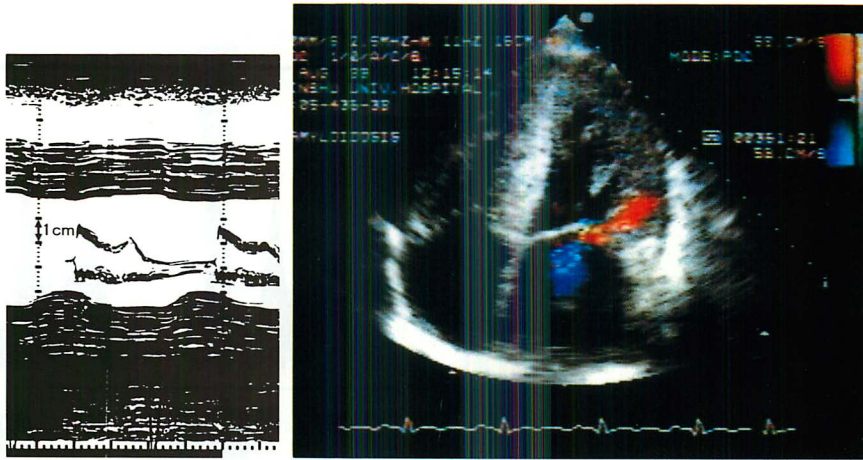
M-mode and two-dimensional color Doppler echocardiograms of a 61-year-old woman with biopsy-proved amyloid heart disease and restrictive ventricular physiology. Note marked ventricular wall thickening with depressed fractional shortening and moderate mitral regurgitation.
